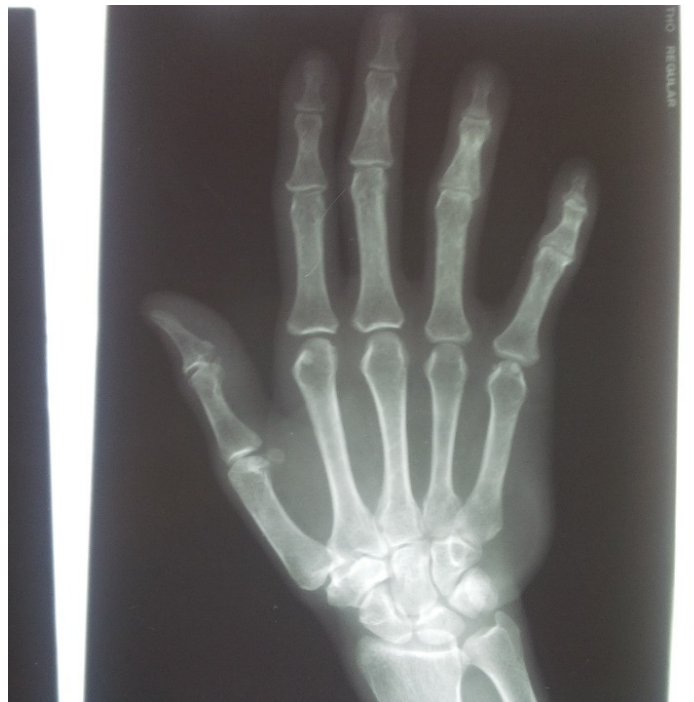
Plain radiograph of the right hand
